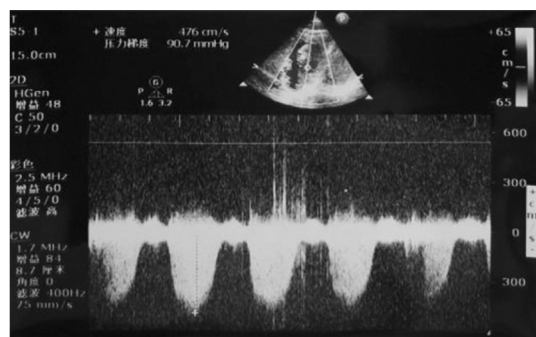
Initial two-dimensional transthoracic echocardiogram showing moderate tricuspid regurgitation with a pulmonary artery systolic pressure of 95.7 mmHg.
